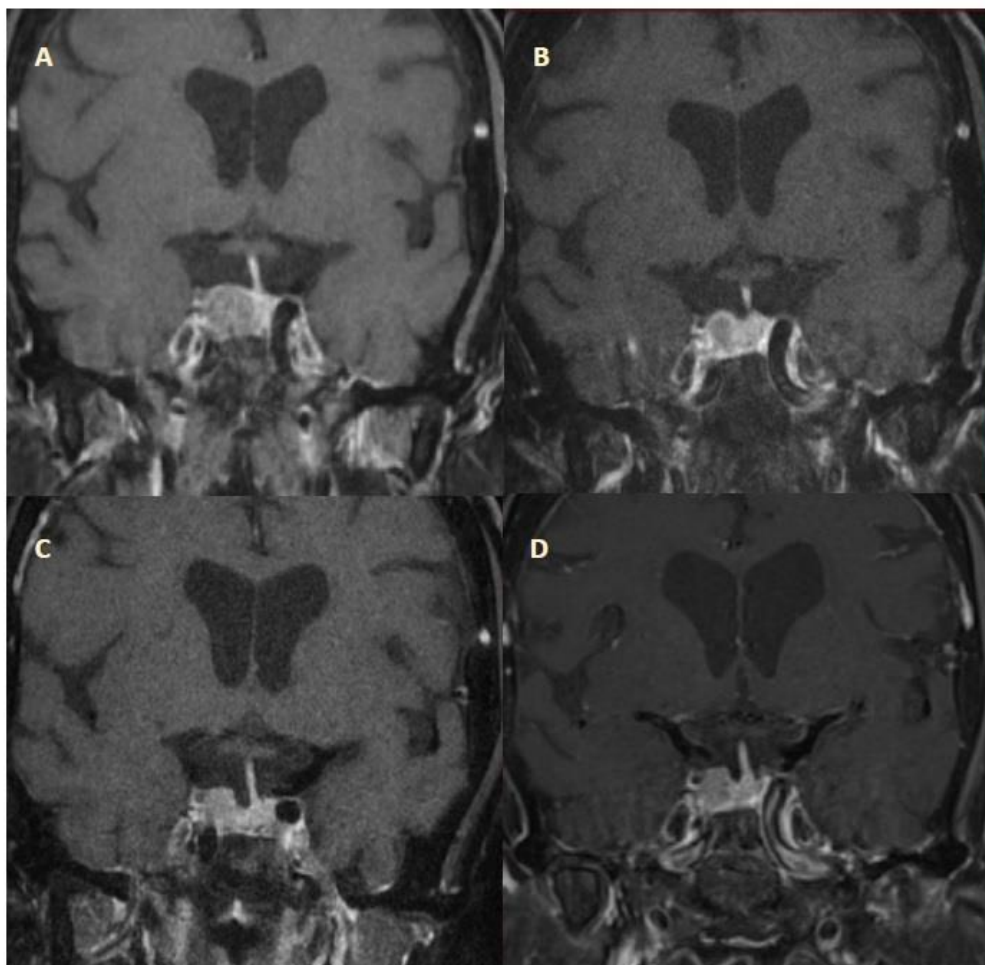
Coronal MRI pituitary view of pituitary macroadenoma over course of treatment. A – Pre-transphenoidal surgery. B – 2 months post-transphenoidal surgery. C – 6 years on subcutaneous pasireotide 360mcg twice daily. D – 5 years with the higher dose of subcutaneous pasireotide 600mcg twice daily (11 years of pasireotide treatment in total).
